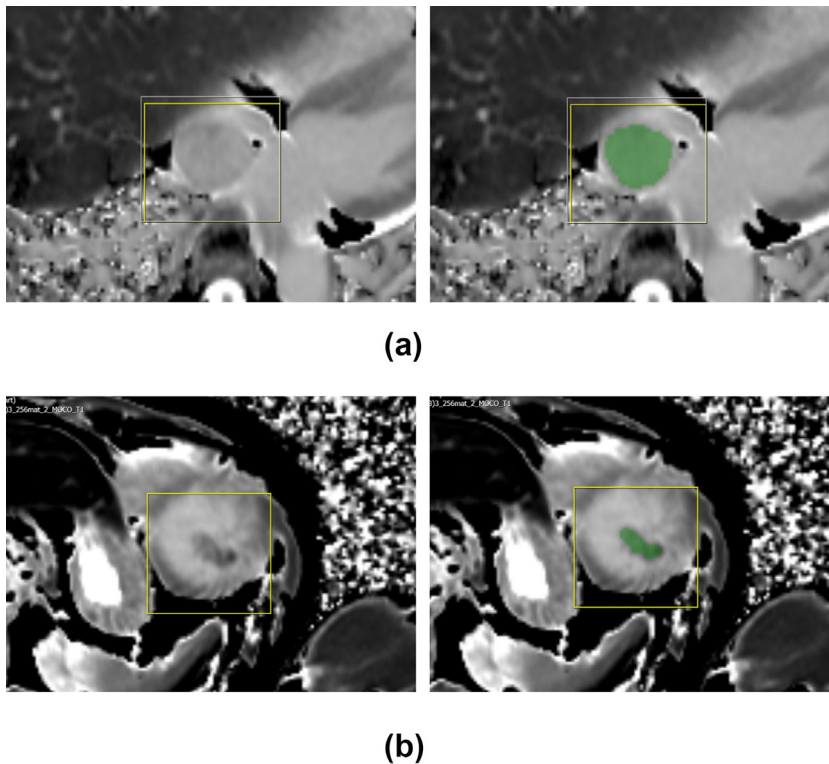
Segmentation example. (a) Images obtained from a 56-year-old woman with no other relevant history. The lesion was located in the right atrium and had a diameter of 17×15 mm. The patient underwent surgery for cardiac mass excision. The lesion was pathologically confirmed as a cavernous hemangioma. (b) Images obtained from a 50-year-old man with a history of dilated cardiomyopathy and arrhythmia. The lesion was located in the left ventricle and had a diameter of 14×11 mm. The lesion completely disappeared on the follow-up echocardiography after 1 month.
